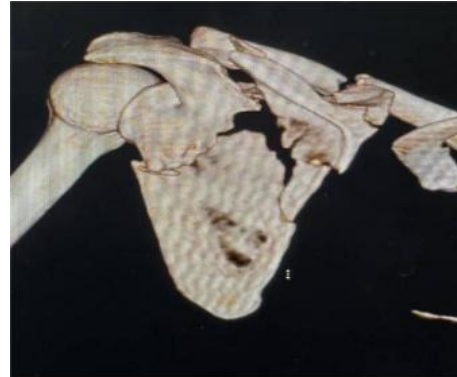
Pre-operative CT imaging
